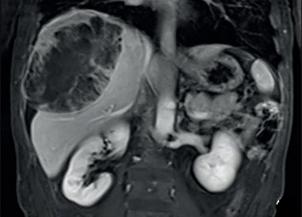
MRI of liver cancer with high expression of Beclin1. Large mass, tumor rupture hemorrhage and necrosis were found.
